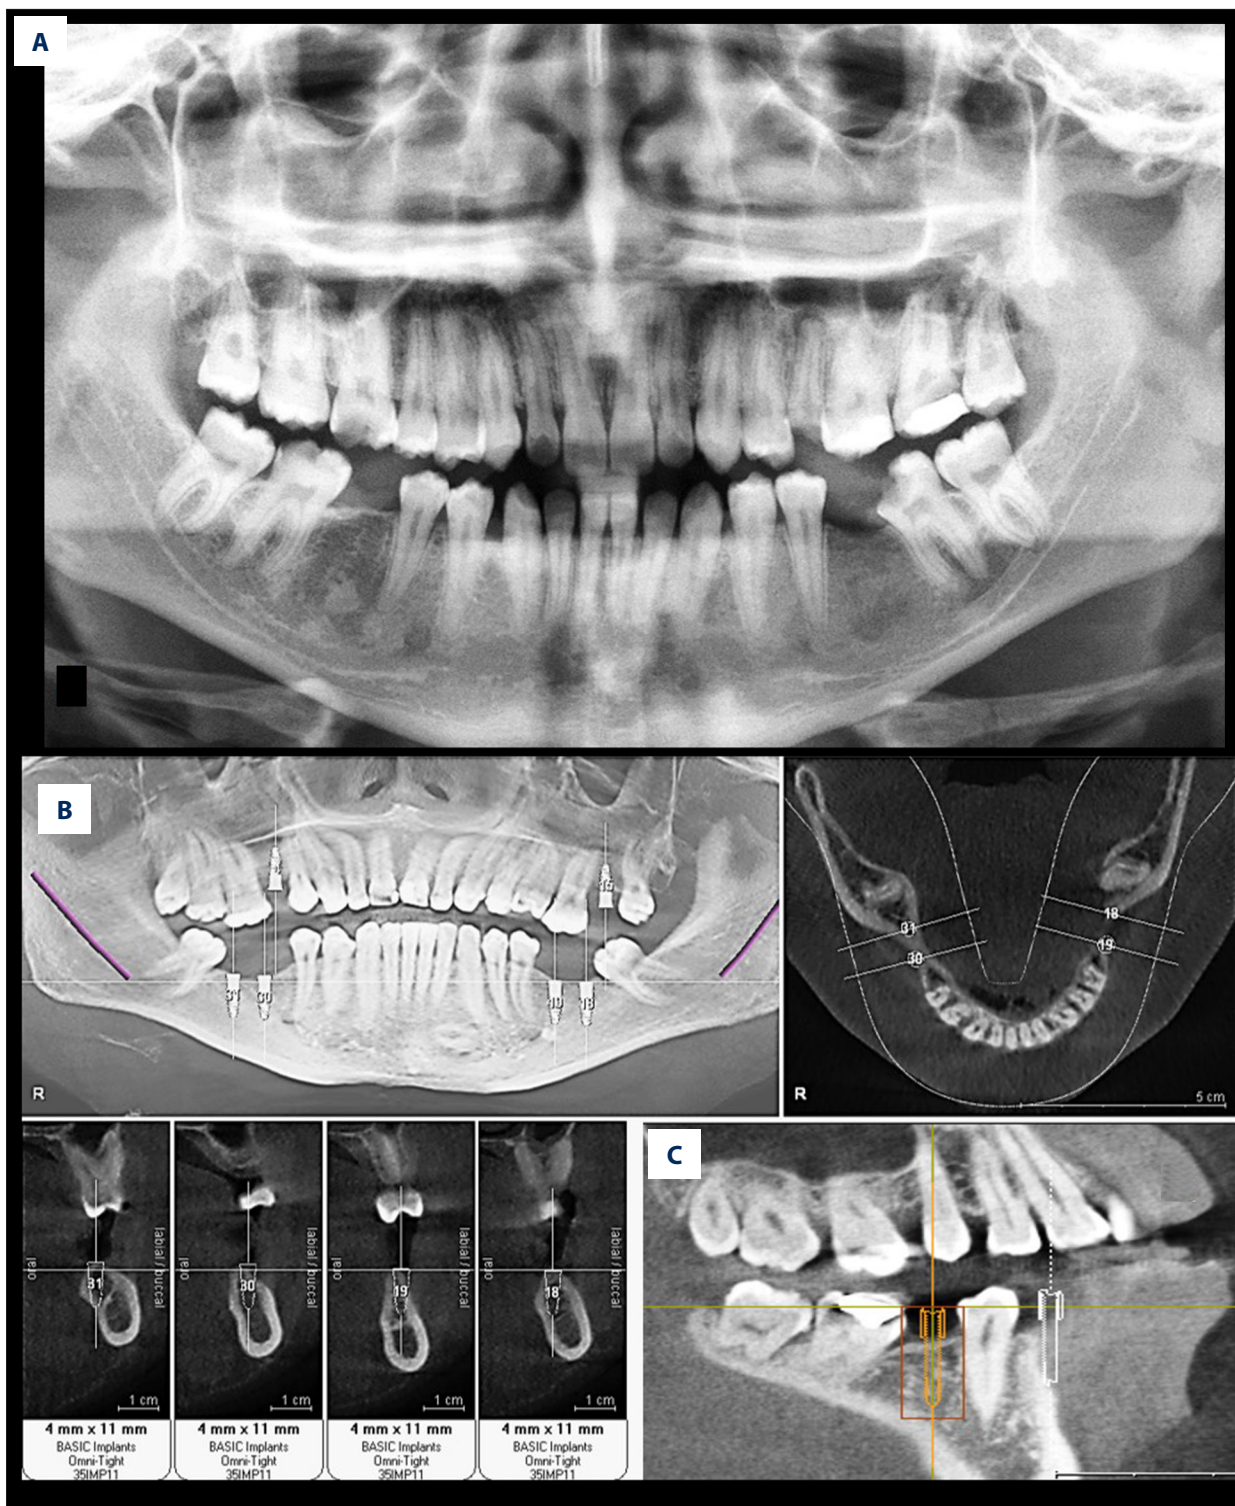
Diagnostic evaluation for implant selection using conventional digital orthopantomograph (A) and cone beam computed tomography (CBCT) (B) and (C). Figure created using MS PowerPoint, version 20H2 (OS build 19042,1466), Windows 11 Pro, Microsoft corporation).
